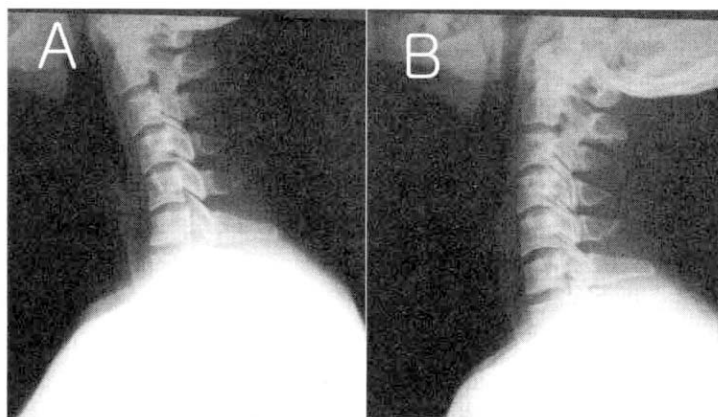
Example patient with kyphosis who had a return to lordosis at follow-up. (A) The patient's lateral cervical radiograph depicts a kyphotic configuration. (B) After 3 weeks(7visits) of a deep acupuncture treatment, the configuration is lordotic
